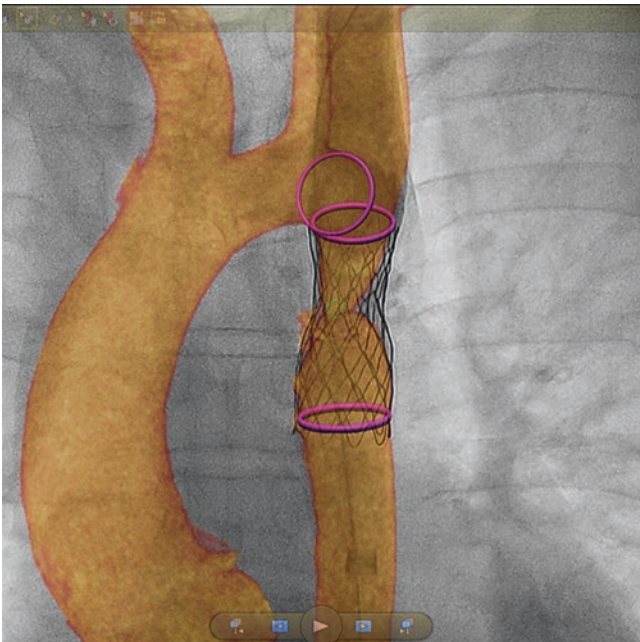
Angiographic result after covered CP stent implantation into a native CoA with the use of overlay by VesselNavigator from CT data. No residual gradient was measured
